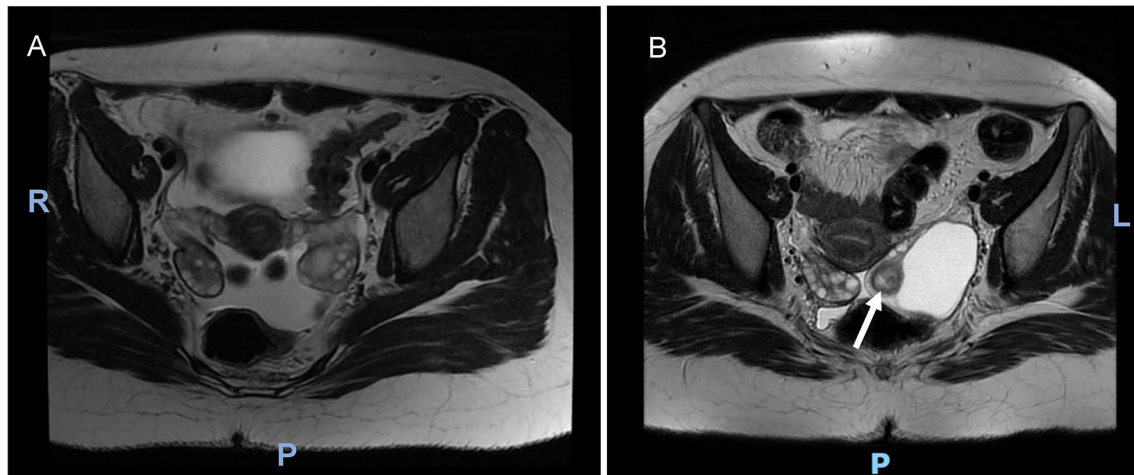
Axial pelvic MRIs with T2 phase. A first MRI performed, with no ovarian abnormalities. B Second MRI, performed 68 days later, showed a left ovarian cyst associated with a 2-cm teratoma (arrow)
